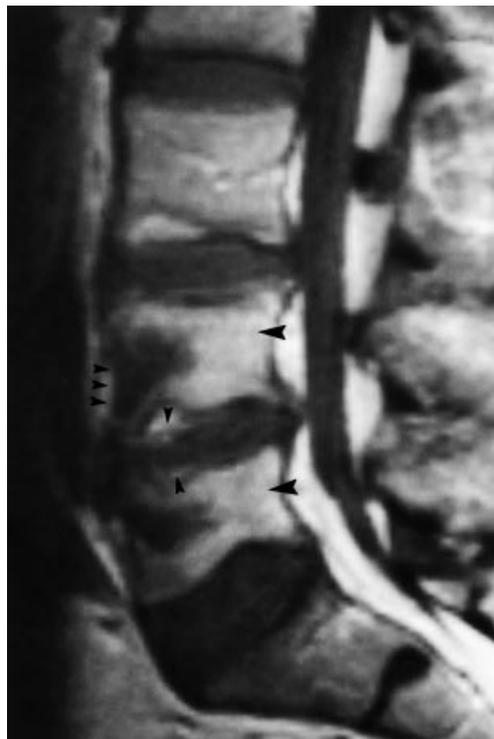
T1-weighted sagittal postcontrast image shows diffuse contrast enhancement within the vertebral bodies (big arrow heads) and linear enhancement within the endplate erosions and along the anterior surface of the vertebral body L4 (small arrow heads).
